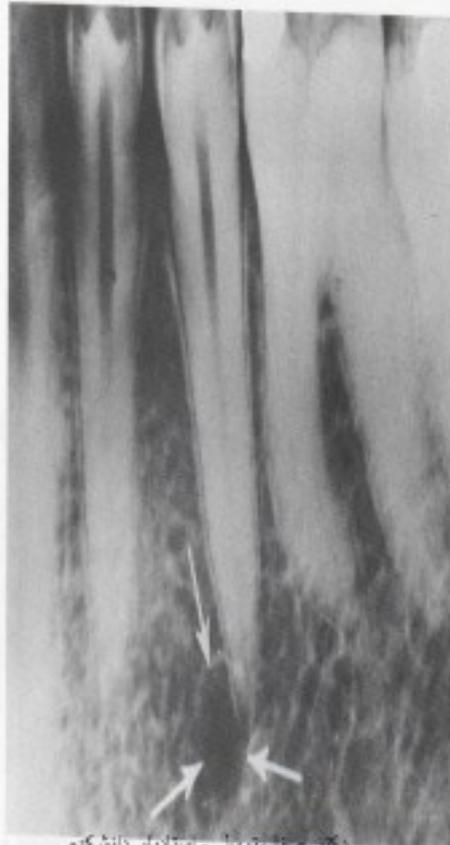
Radiographs in locating the mental (arrows). (Courtesy D. Zelem.)
